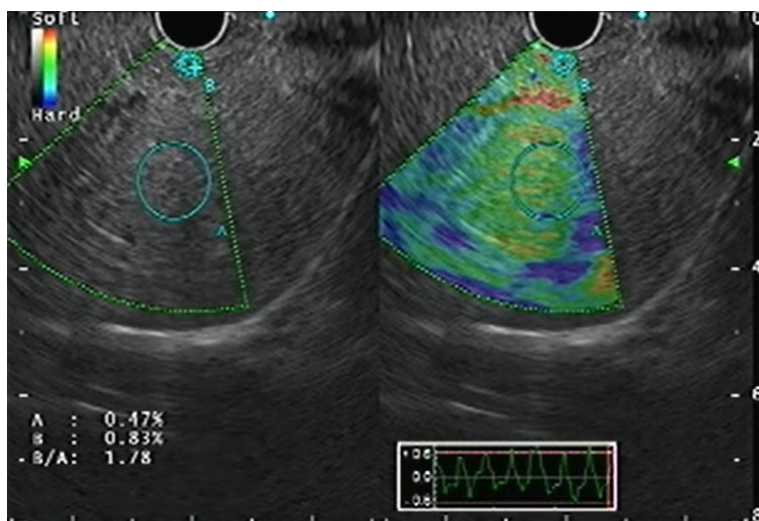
Endoscopic ultrasound elastography of the liver parenchyma.
